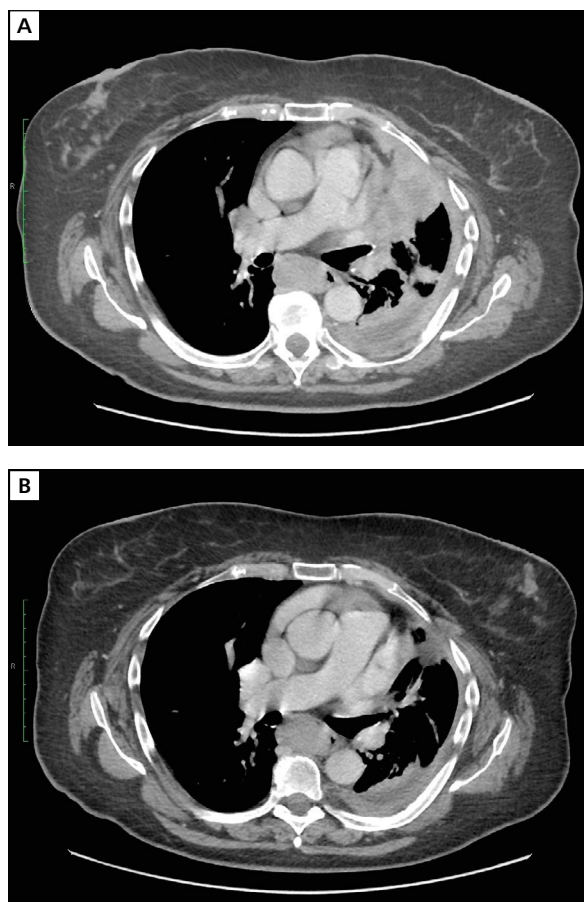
Computed tomography (CT) scans of November 15, 2021 (A) and February 3, 2022 (B) showing partial remission of the disease: reduction in the primary tumor dimensions, reduction of the pleural effusion and lack of enlarged mediastinal lymph nodes
